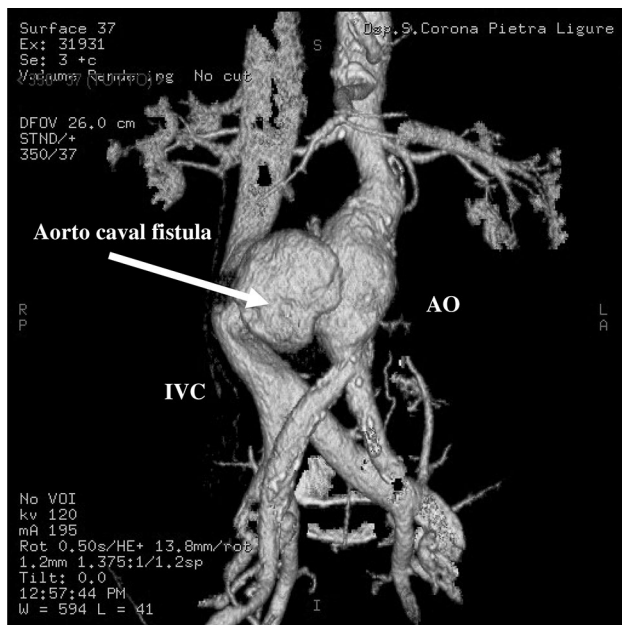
CT scan: three of the four typical CT findings of ACF on CT are present in this slice. Early contrast enhancement of the inferior vena cava, which has the same density of the adjacent aorta, an associated aortic aneurysm, and loss of normal anatomic space between aorta and inferior vena cava (arrow). Contrast computed tomography simultaneously showed an abdominal infrarenal aortic aneurysm (7 × 9 cm) with communication between the aorta (AO) and the inferior vena cava (IVC). On the right you can see the true and the false lumen of the aortic aneurysm, and on the left the aortocaval fistula (arrow)
